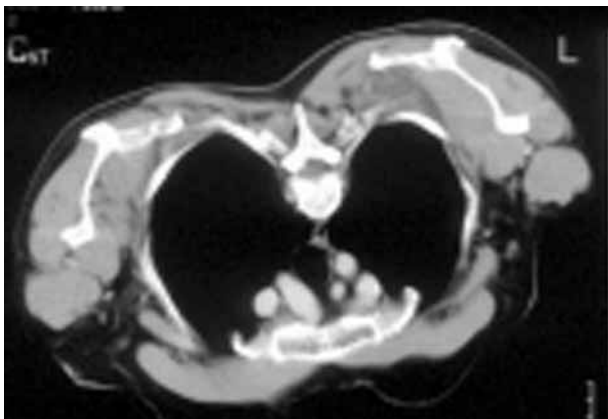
CT scan after contrast injection demonstrates a left subscapular ill-defined soft tissue mass with a predominance of fat within the lesion. No contrast enhancement was detected.
